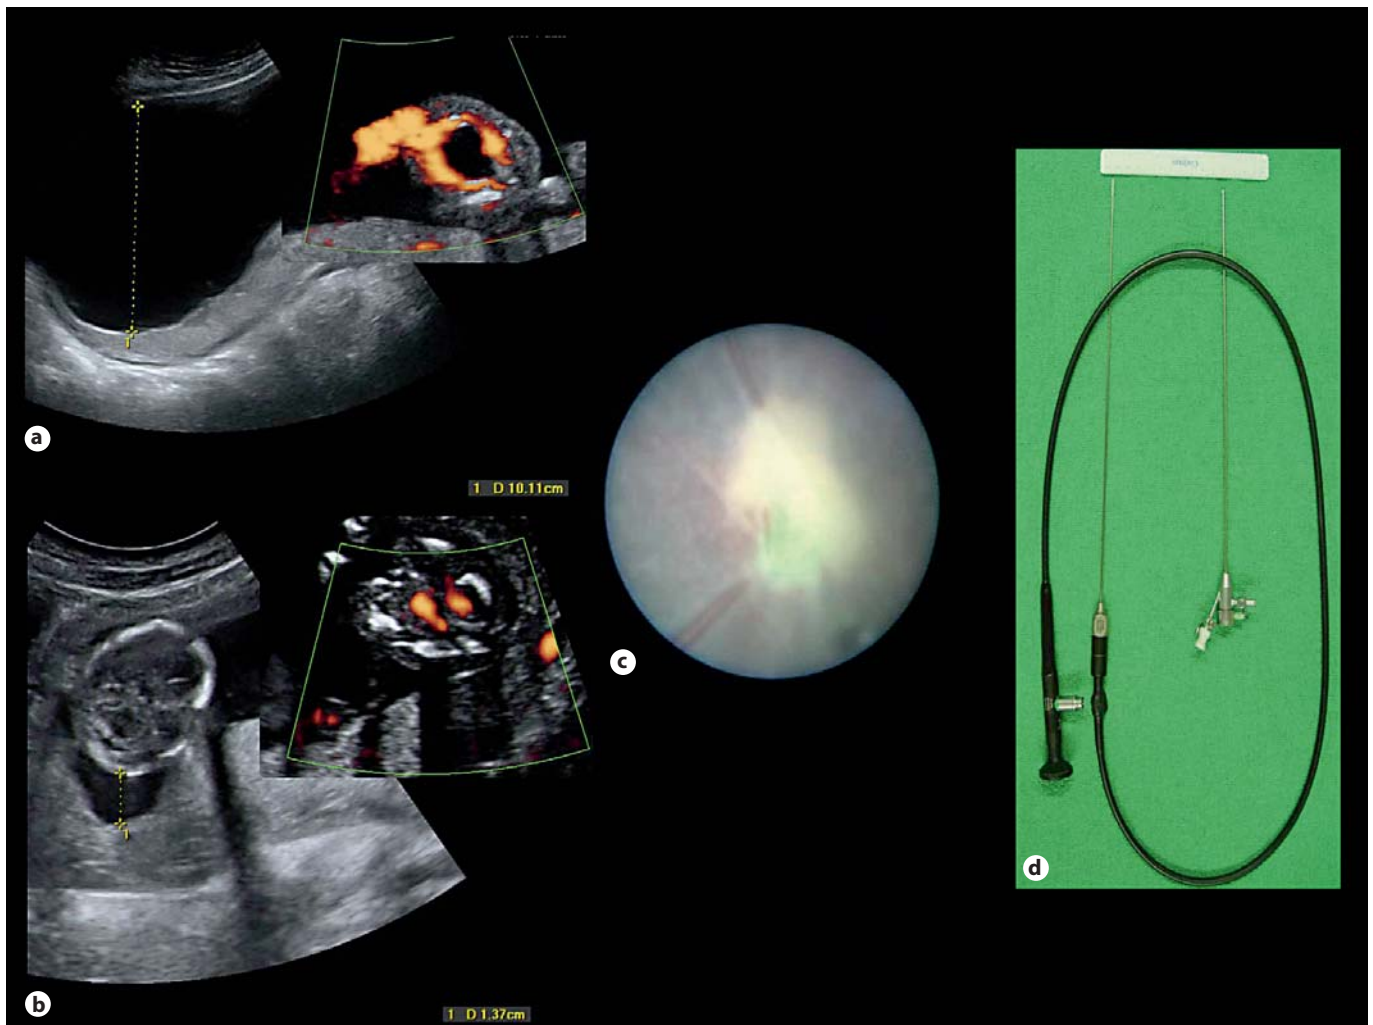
a Ultrasound image of the polyuric polyhydramnios in the recipient twin in a TTTS case diagnosed at 20 weeks with a deepest vertical pocket >10 cm. b Ultrasound image of the oliguric oligohydramnios of the co-twin with a deepest vertical pocket of 1.4 cm. c Fetoscopic image of laser coagulation of an artery-to-vein anastomosis. d Fetoscope (2 mm in diameter and 30 cm in length) with remote eyepiece and straight sheath with a channel for laser fibers up to 600 μm (Storz, Tuttlingen, Germany).
